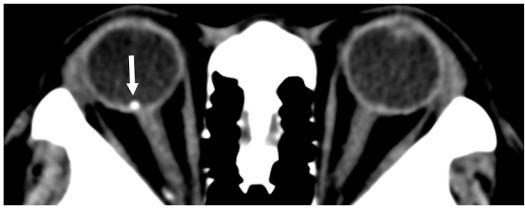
Axial CT showing a calcified focus along the retina posteriorly consistent with a calcified astrocytic hamartoma in a patient with known tuberous sclerosis (*white arrow*).
